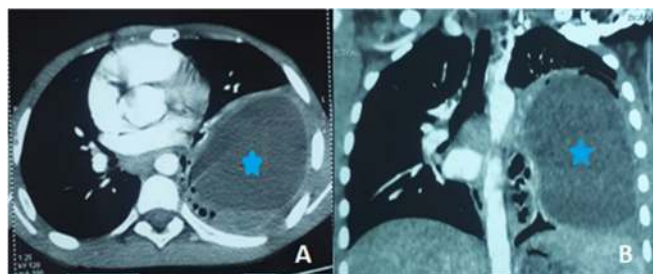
Thoracic computed tomography scan showing an intact hydatid cyst (marked with a star) of the left lung: axial (A) and coronal (B) sections.
